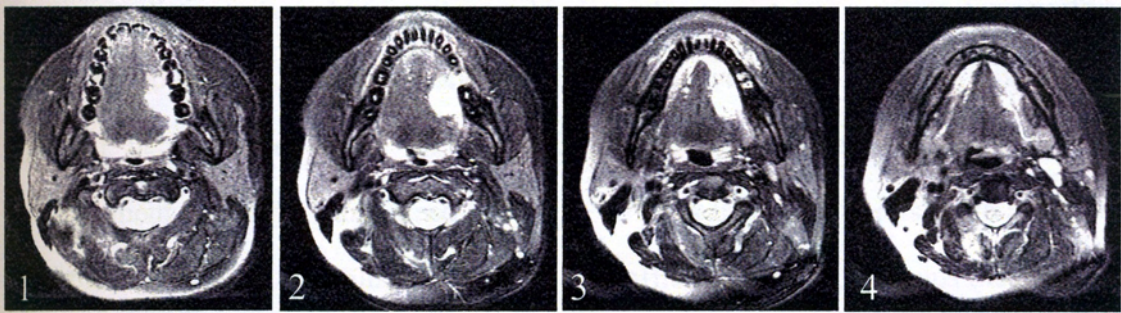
Four MR images with tongue carcinoma from the same patient
